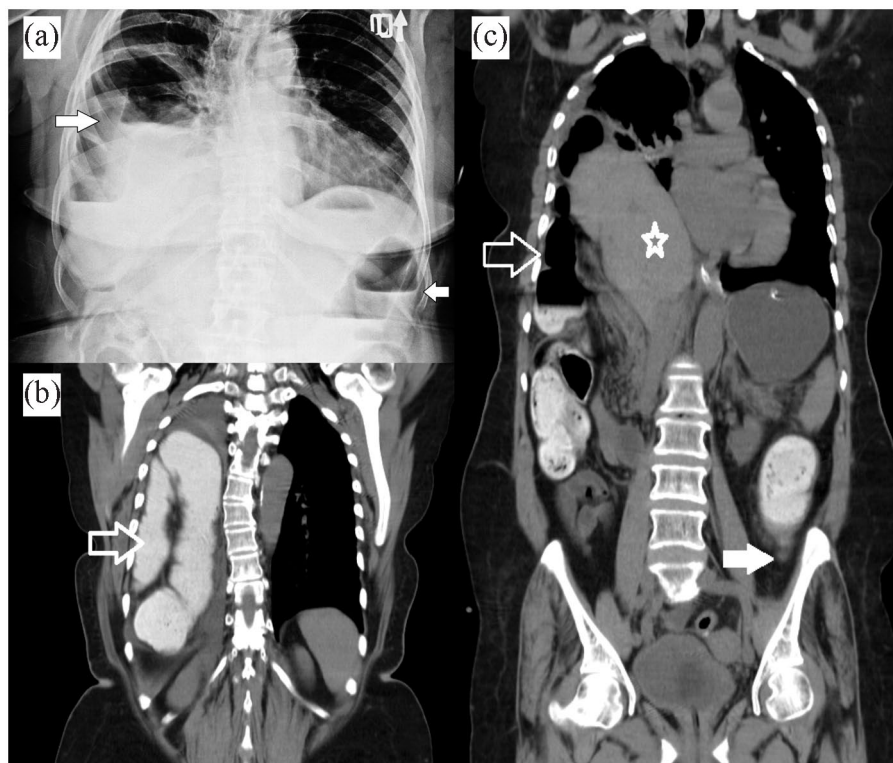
Initial radiographic images of the adult right-sided BH (before surgery): (a) an upright Chest X-ray left arrow showing air-fluid level, right arrow showing the column air-fluid level in the right hemithorax and left directed arrow showing the column air-fluid level in the descending colon, (b), (c): Coronal sequences of thoracoabdominal CT scan showing herniation of liver (white star), ascending and transverse colon (white empty arrow) into hemithorax with the obstructed site of descending colon (white full field arrow, bird beak sign).
